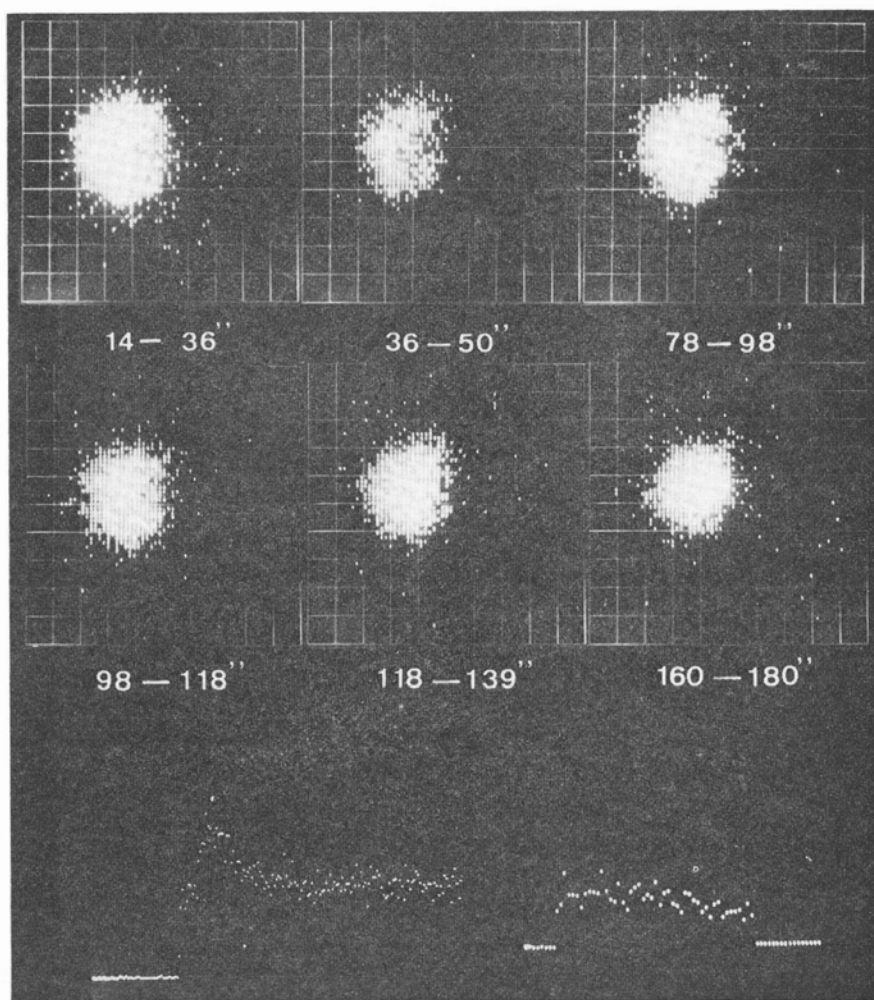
Serial scintigraphy replayed on the oscilloscope and functional curves of the whole kidney and the renal cortex (each signal corresponds to 3 sec) after intra-arterial applied 1 mCi ^{131}I -o-Iodohippuric acid in a patient with slight hydronephrosis due to the compression of the renal pelvis by a small tumor. Note the reduced area in the second and sixth scintiphoto corresponding to the delayed but proved transport of the radioactivity through the nephrons.
